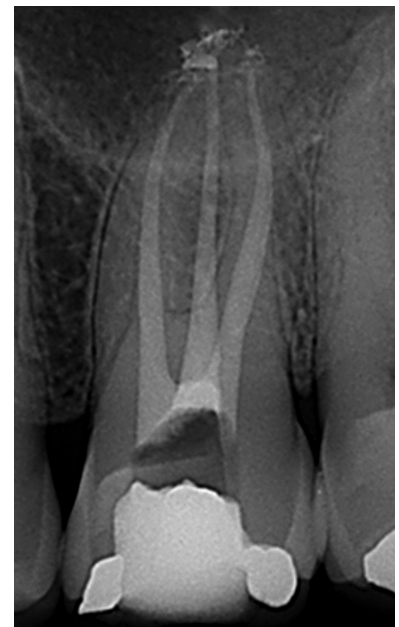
Postoperative radiograph after canal obturation with Guttacore obturators (Dentsply/Maillefer)
